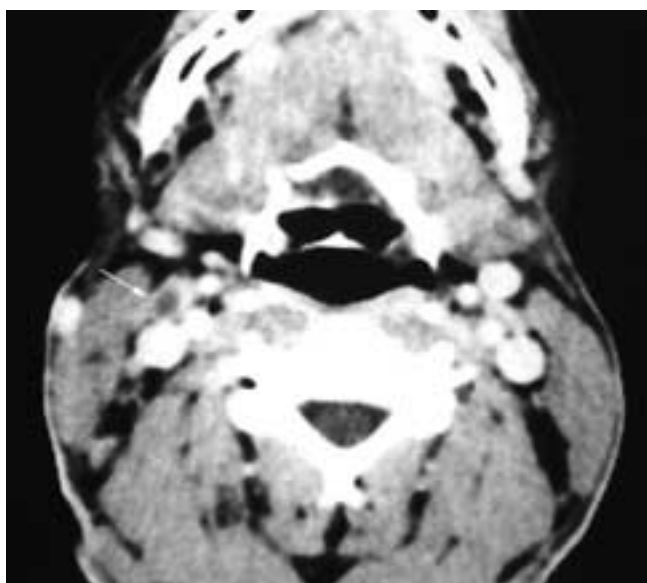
Axial contrast-enhanced CT scan shows a right level II node (*arrow*) that is normal in size and sharply delineated from the adjacent fat planes. However, the node has central necrosis and an unevenly thick, enhancing nodal rim. This was a metastatic squamous cell carcinoma node.
